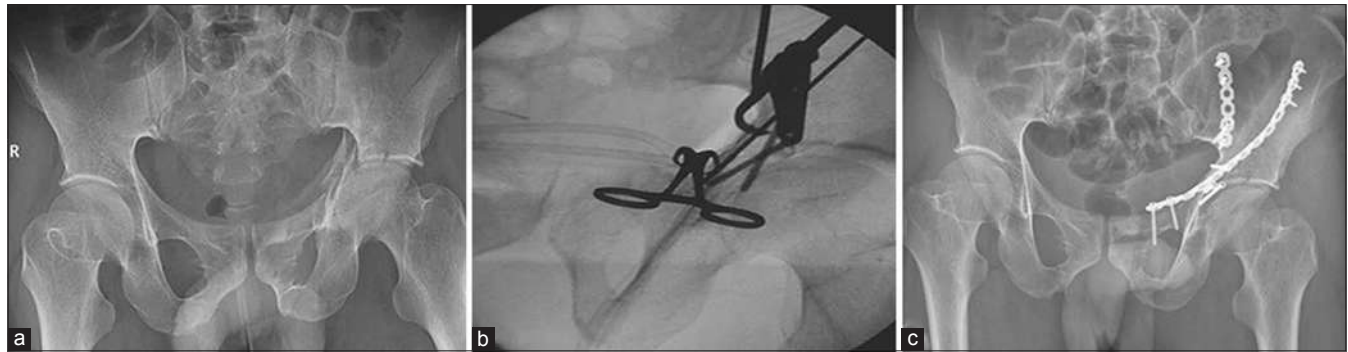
(a) X-ray pelvis with both hip joints anteroposterior view of a man, 46 year-old showing T-shaped acetabular fracture in his left hip. (b) Fluoroscopy image showing the usage of reduction clamp during operation. (c) Postoperative film showing that the fracture is well reduced and fixed with lag screws and reconstructive plates
